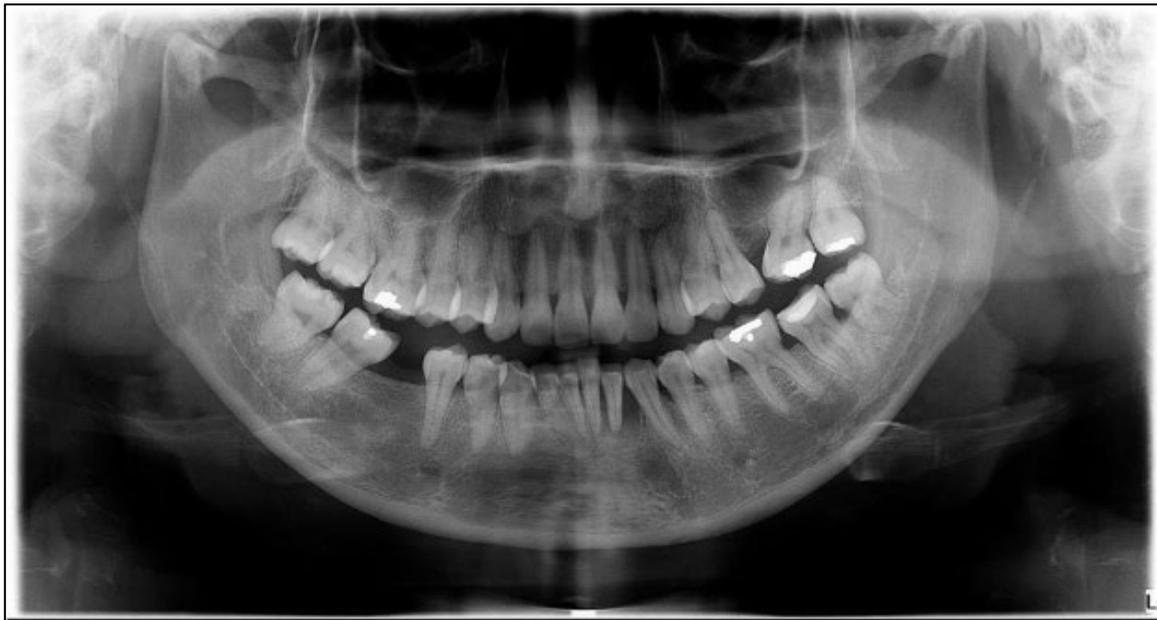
Panoramic radiograph (Orthopantomography) of Case 3.
